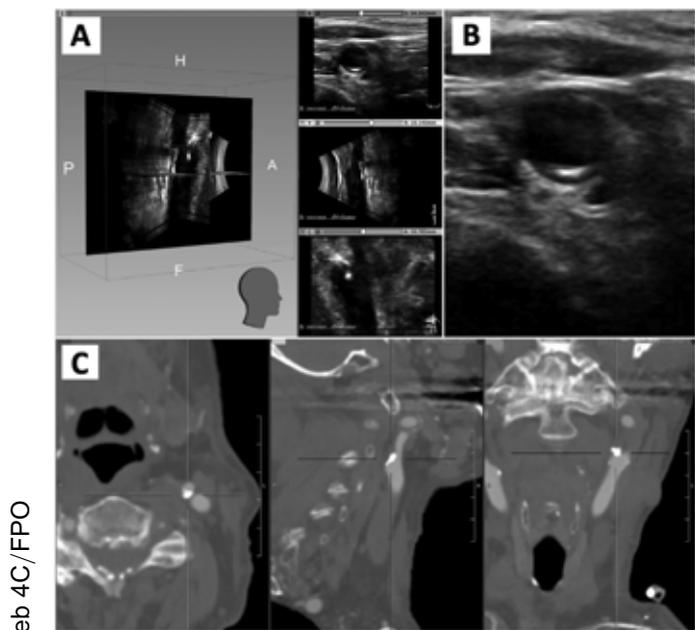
3DUS with axial, sagittal, and coronal 2D images. B: Source 2DUS. C: Axial, sagittal, and coronal CTA.
